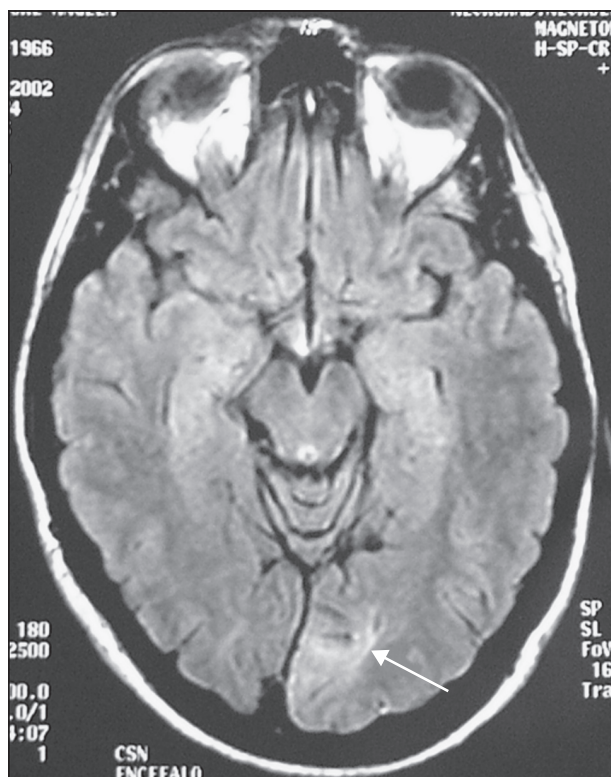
Brain MRI, axial FLAIR image: hyperintense signal area in left occipital cortico-subcortical regions (see arrow).
